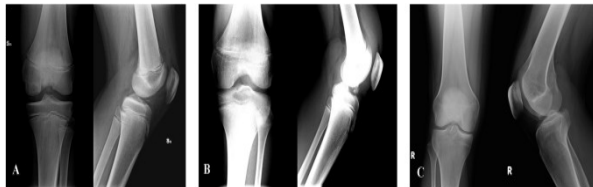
Pre-operative X-ray assays: case n.1 (A), case n.2 (B) and case n.3 (C).
